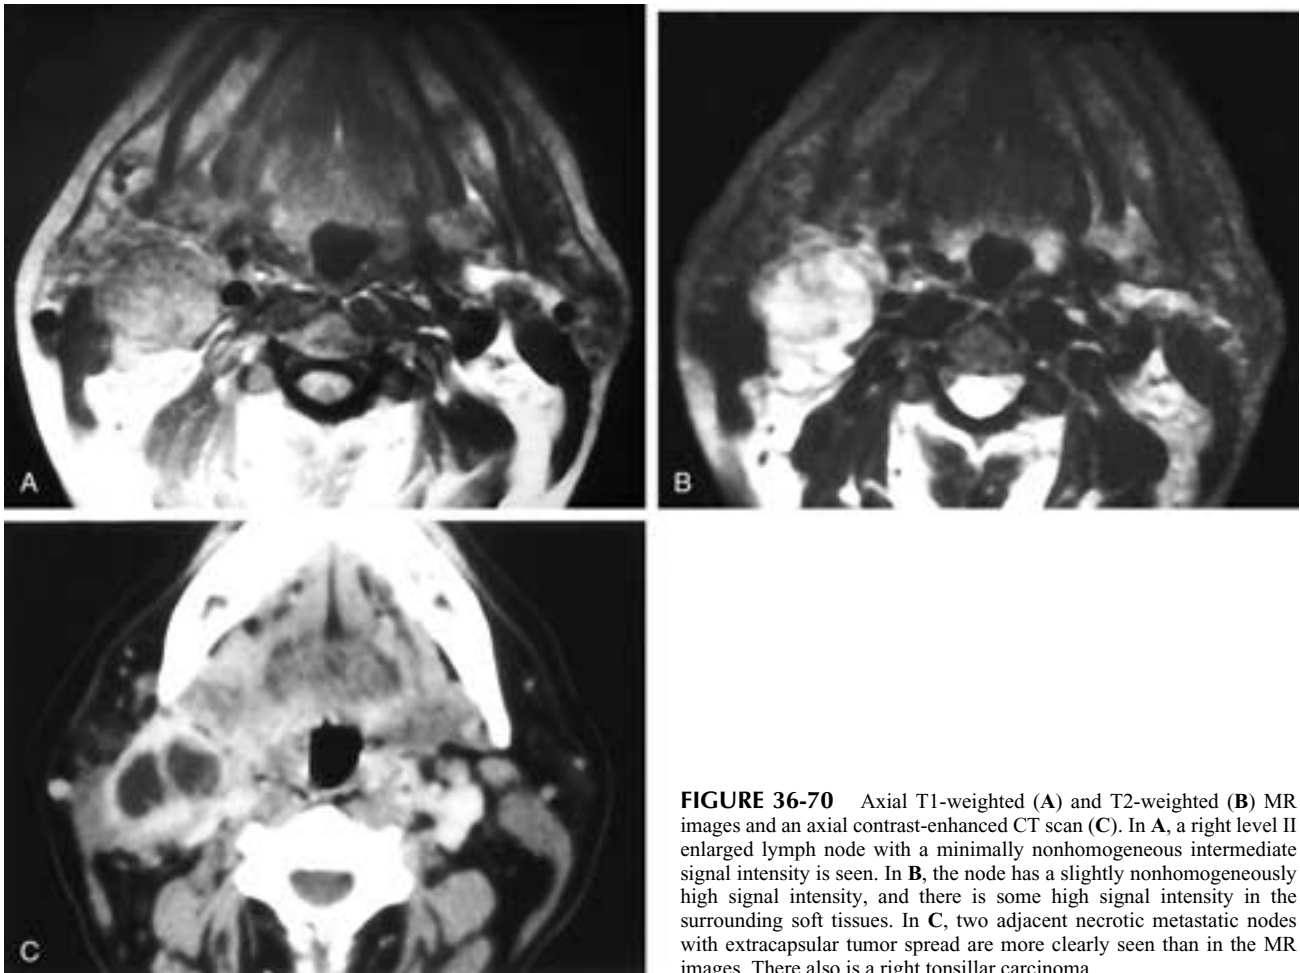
Axial T1-weighted (A) and T2-weighted (B) MR images and an axial contrast-enhanced CT scan (C). In A, a right level II enlarged lymph node with a minimally nonhomogeneous intermediate signal intensity is seen. In B, the node has a slightly nonhomogeneously high signal intensity, and there is some high signal intensity in the surrounding soft tissues. In C, two adjacent necrotic metastatic nodes with extracapsular tumor spread are more clearly seen than in the MR images. There also is a right tonsillar carcinoma.
